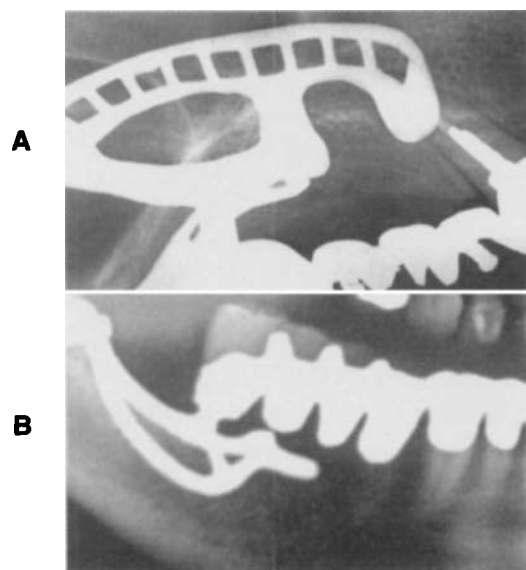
■ Postoperative radiographs of maxillary (A) and mandibular (B) unilateral subperiosteal implants.
